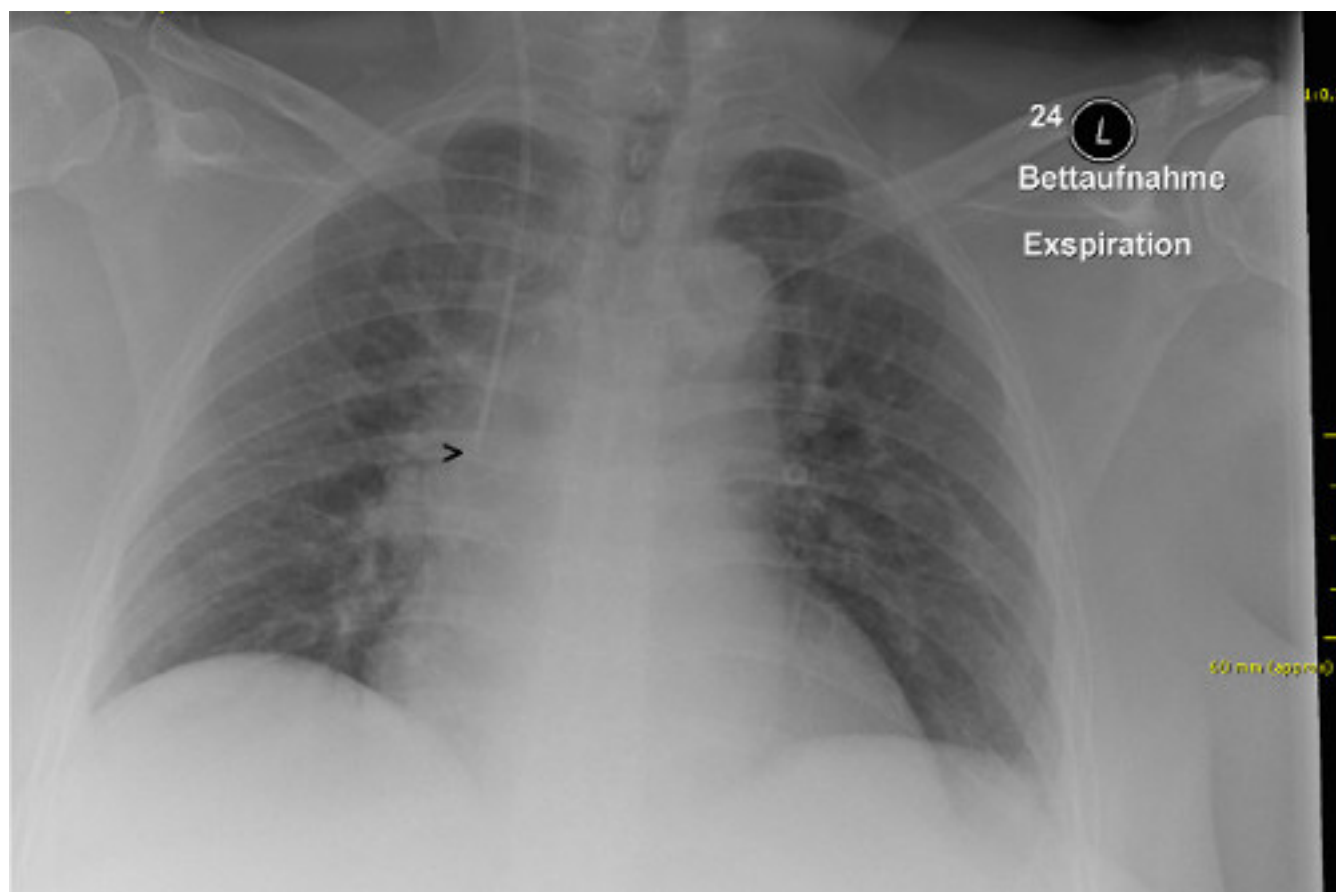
Representative chest radiograph following ultrasound-guided CVC tip positioning in supine position and expiration. The CVC tip (arrow) is in projection of the distal superior vena cava.
